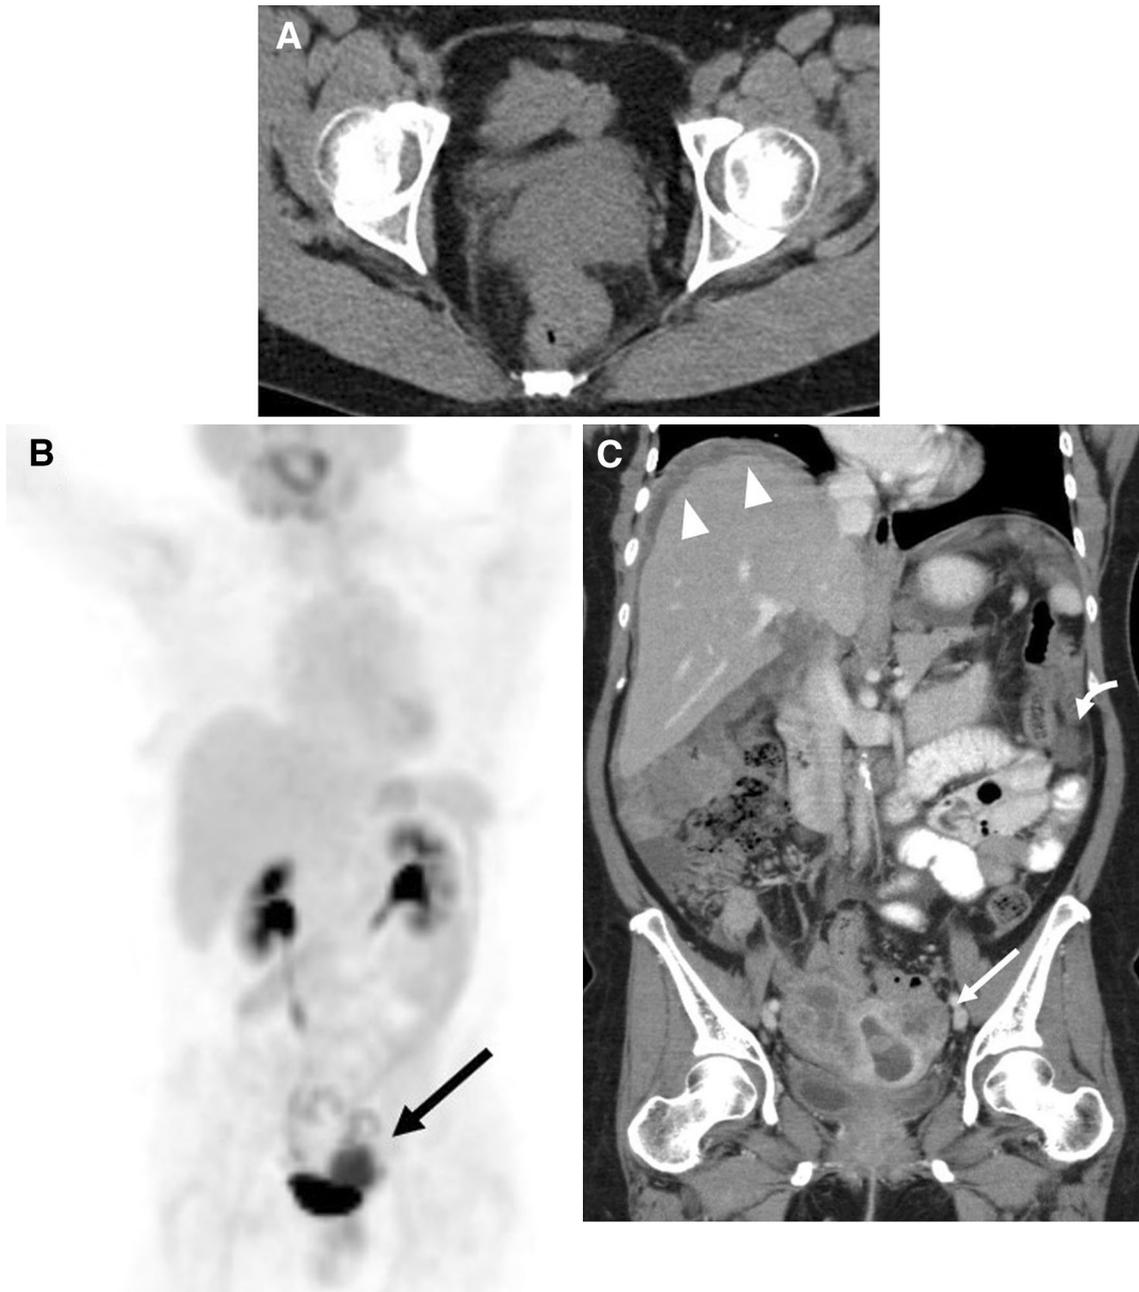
48-year-old woman presenting with abnormal vaginal discharge and pelvic discomfort and an enlarged irregular cervix on pelvic exam. The cervix was biopsied, demonstrating adenocarcinoma of the cervix extensively involving the cervical stroma. A 18F-FDG PET/CT MIP image shows a hypermetabolic cervical mass with no FDG lymph nodes in pelvis and relative axial CT image (B) shows a
